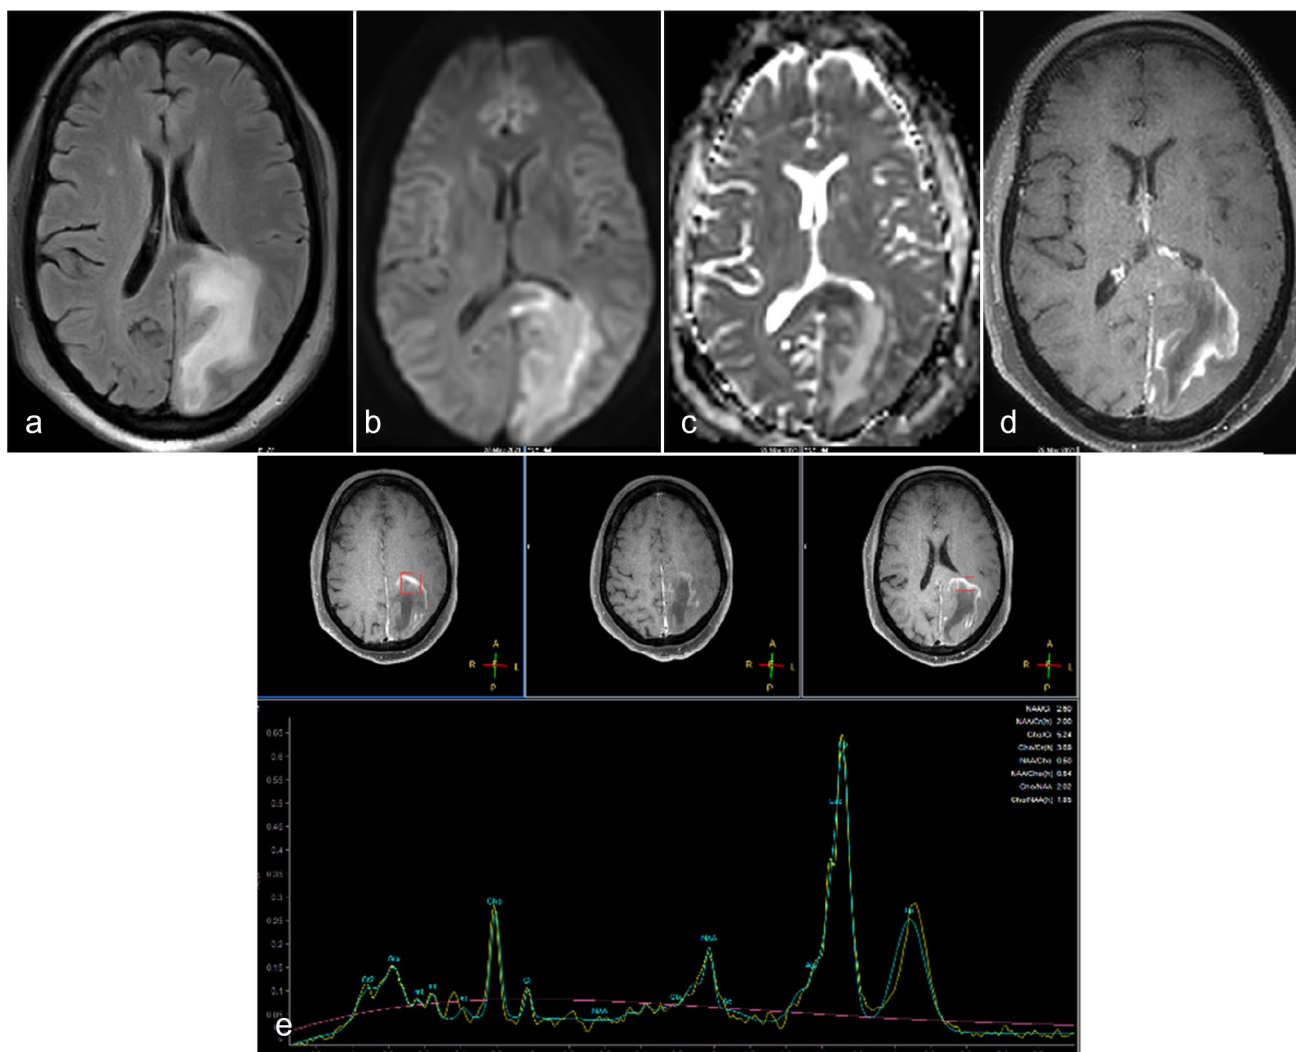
MRI (a–e) images shows a well-defined FLAIR hyperintense mass lesion (a) involving subcortical, deep and periventricular white matter of left parietal and occipital lobe extending into splenium of corpus callosum on left side with peripheral diffusion restriction (b
